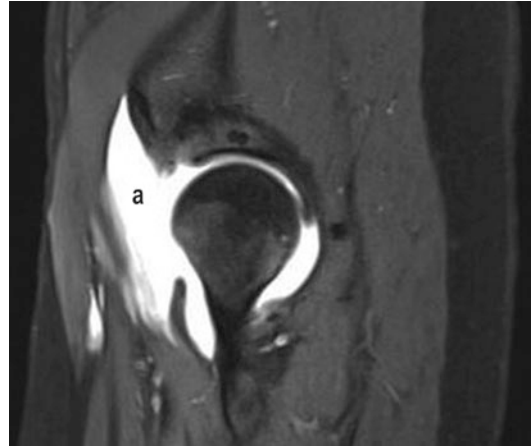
MRI of a healthy 30-year-old female who experienced an anterior hip dislocation after hip arthroscopy with an unrepaired interportal capsulotomy. The MRI shows significant contrast extravasation through a gross capsular defect (a) (Image reproduced with permission from Yeung et al. [83])
